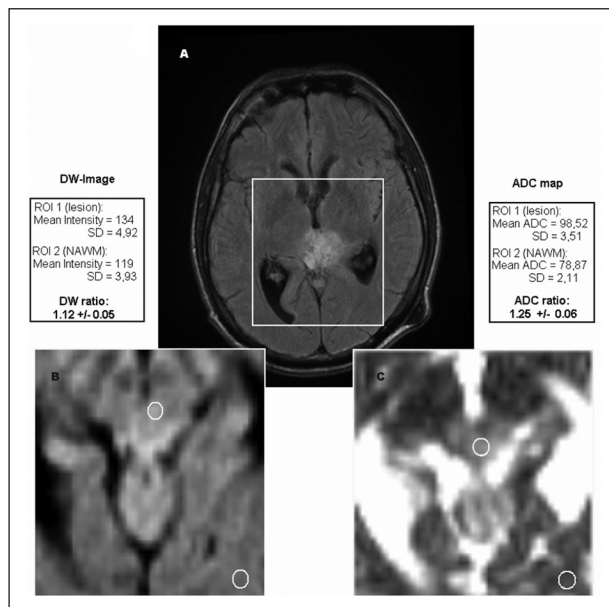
MR imaging after treatment: (A) FLAIR image demonstrates the hyperintense pineal mass. (B) DW image shows discrete high signal and a DW ratio of 1.12. (C) ADC map demonstrates increased mean ADC ratio (1.25).
